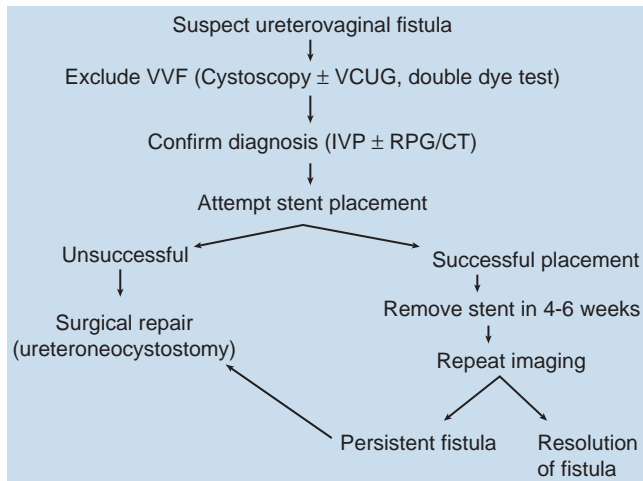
Algorithm for diagnosis and management of ureterovaginal fistula. CT, computed tomography; IVP, intravenous pyelography; RPG, retrograde pyelography; VCUG, voiding cystourethrography; VVF, vesicovaginal fistula.
